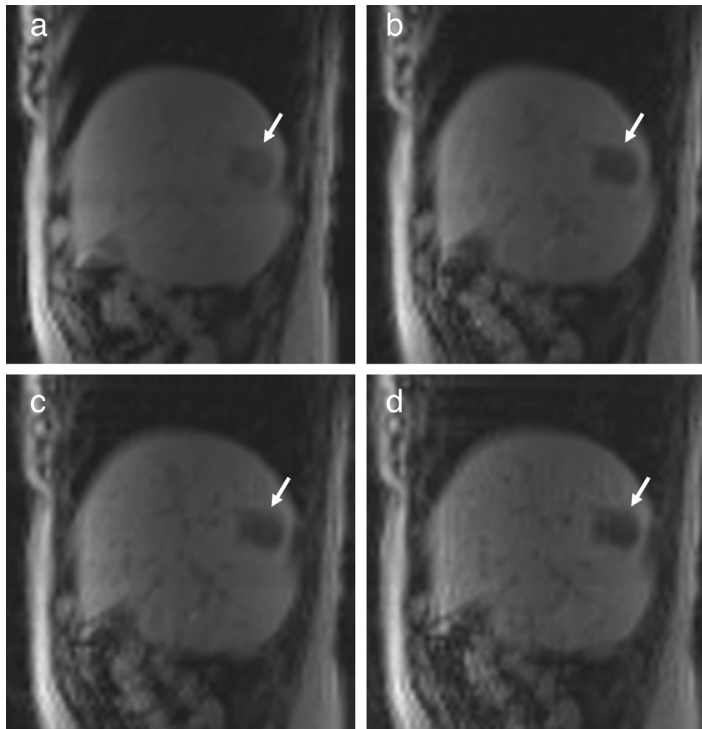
Measurement series (a, b). Real-time T1-weighted gradient-recalled echo sequences showing sagittal planes with different flip angles performed in increasing order (measurement series 1a), 15°, 30°, 45°, and 60° (a-d). Note the different conspicuity of the hypointense target lesion (arrows) and vascular structures and the different extent of artifacts. Measurement series 1b in decreasing order (60°, 45°, 30°, and 15°) showed similar results.
